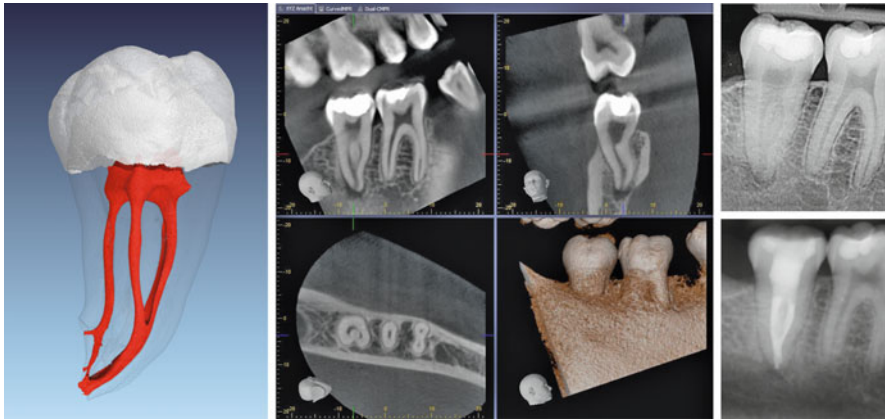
Micro-computed tomography image of an extracted second mandibular molar with C-shaped canal configuration (*left*). CBCT (*middle*) and X-rays before and after treatment (*right*) of a similar clinical case
